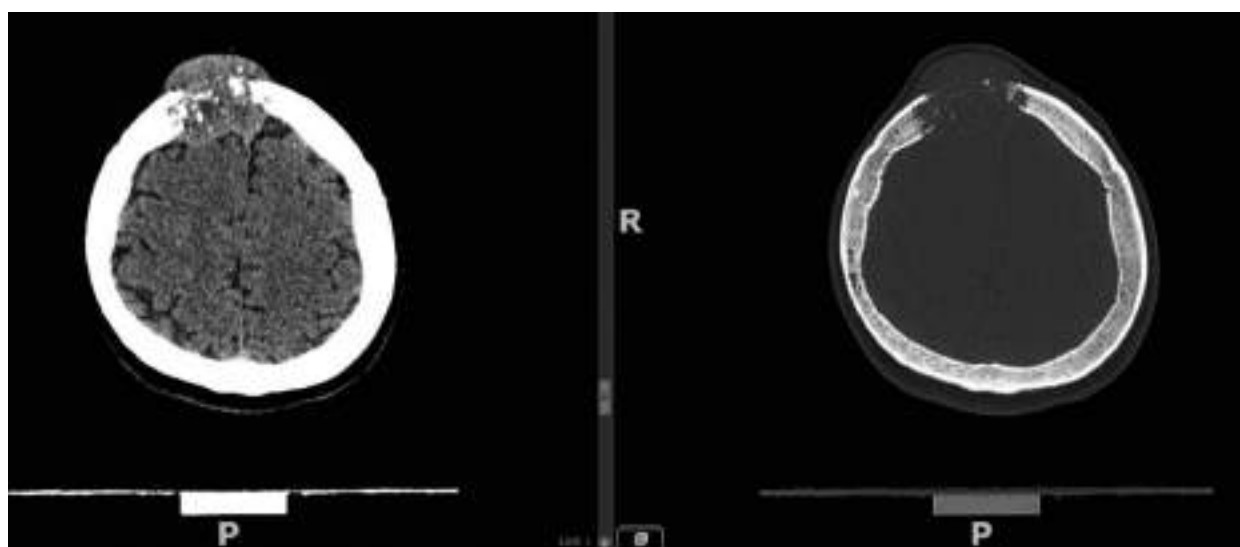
Preoperative endocranial CT – osteolytic lesion
